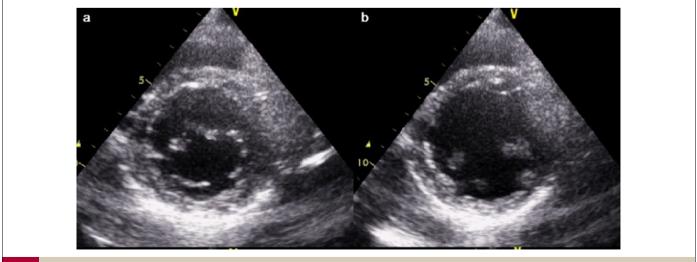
2D echocardiogram short-axis views at mid-cavity level showed a dilated left ventricle with poor contractility. (A) End-systolic frame. (B) End-diastolic frame.
